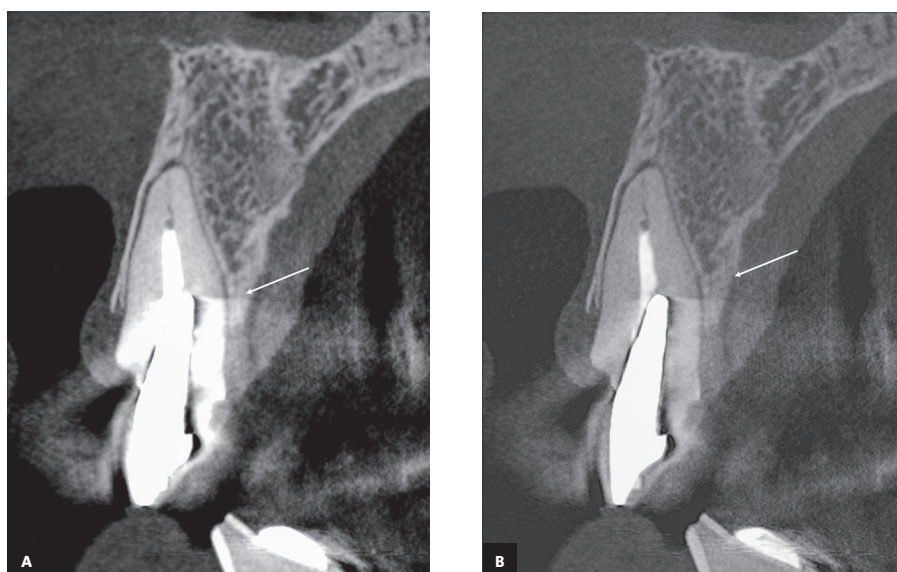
The CBCT scans (A) exhibit the tooth #21 with root canal treatment, and an extensive intraradicular post somewhat displaced to the palatal area, whose white contrast artifact made it difficult to rule out presence or absence of a root fracture accurately; (B) In the artifact filters applied using the e-Vol DX software, and it may be verified that although the root canal was not completely filled, no imaging findings associated with a root fracture were observed.
